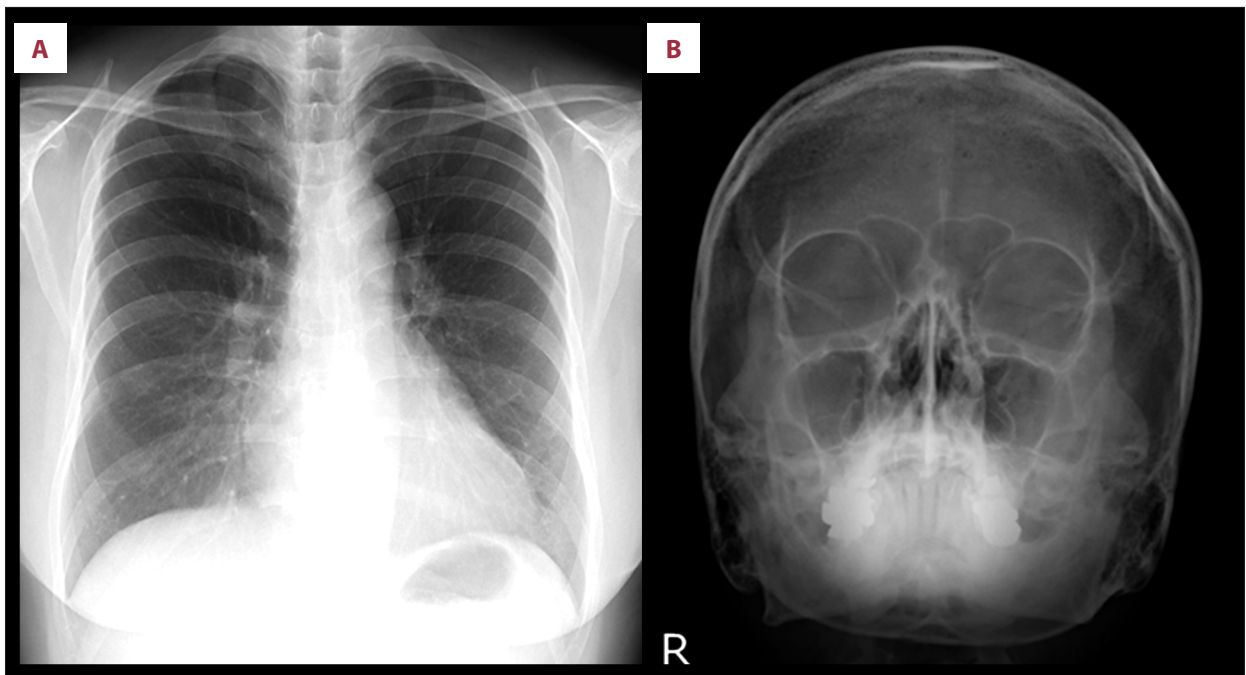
Chest (A) and sinus (B) x-ray films of our patient. (A) Chest radiograph of the patient on initial presentation shows no signs of pulmonary infiltrates or consolidation. (B) Sinus radiograph did not show any signs of mucosal thickening.
